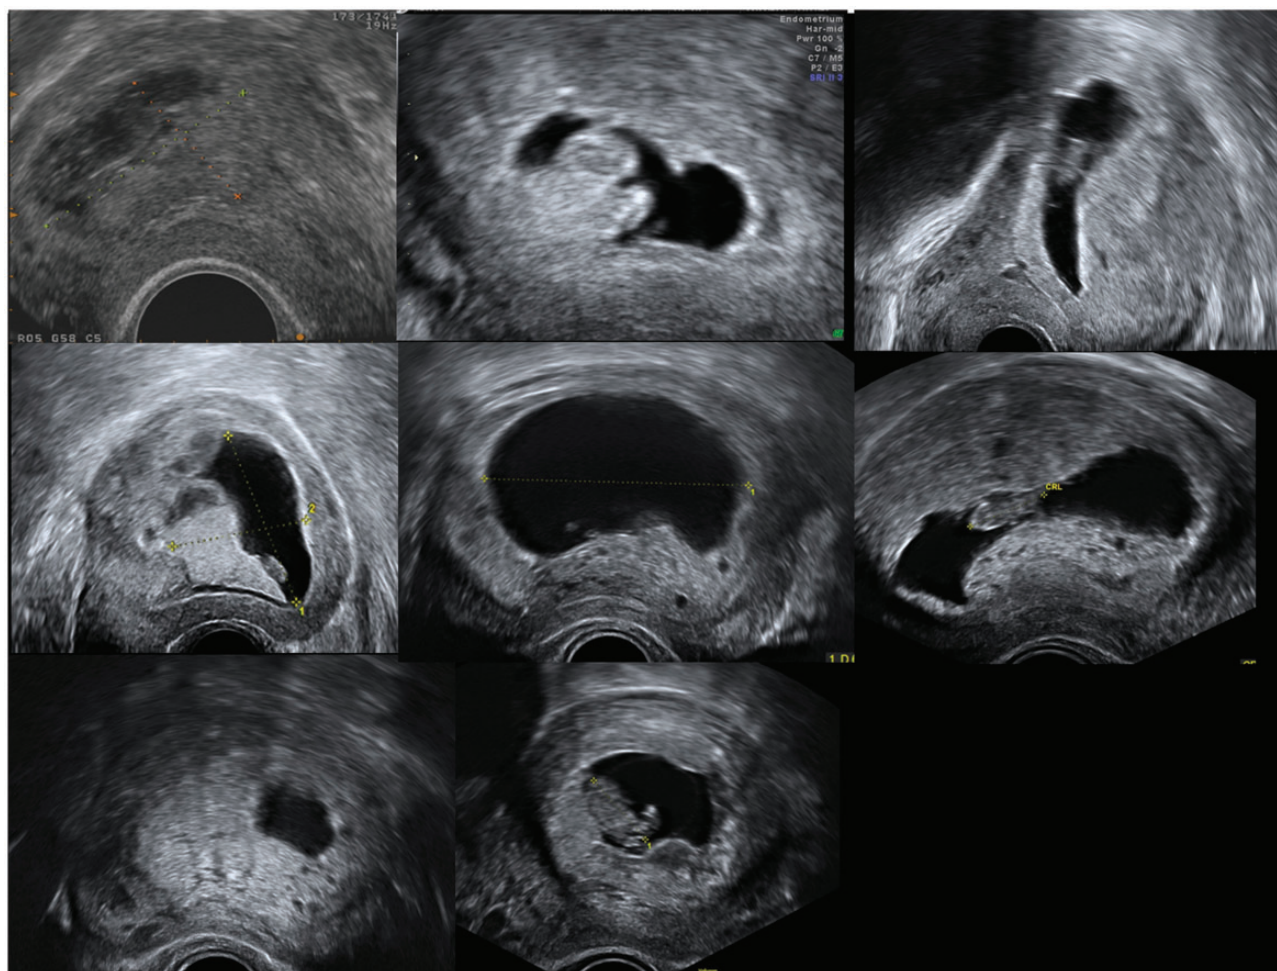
Missed partial molar pregnancies (false negative ultrasound scans).
